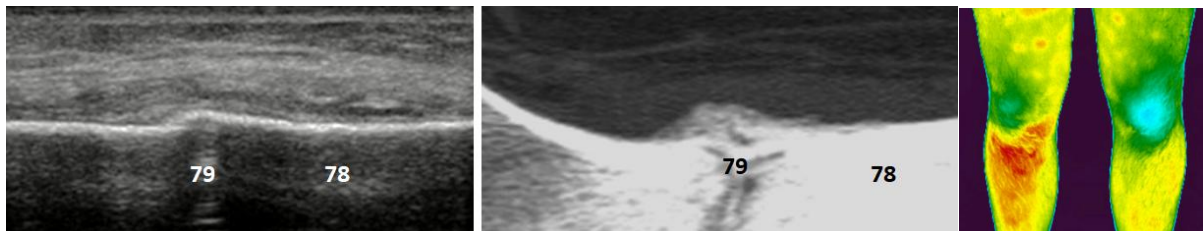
sono Fig.9b.CT, Fig.9c.TMV. Sono, CT: fracture of the medial condyle of the tibia on the right. TMV: increased thermal activity of tibia proximal medially and anteriorly. 78. tibia, 79. fracture.
